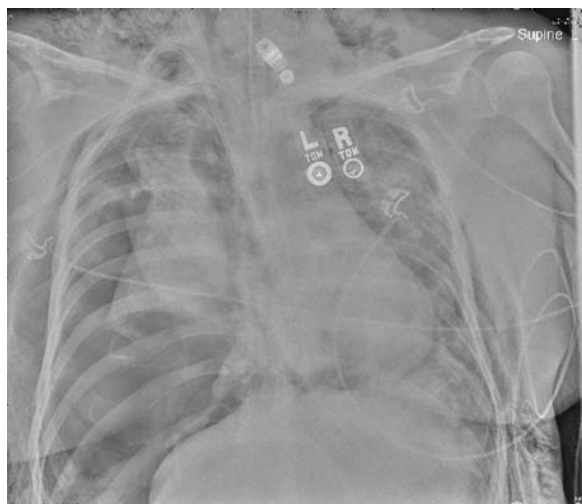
Tension pneumothorax in a patient receiving mechanical ventilation for ARDS. There is a large pneumothorax on the right with associated collapse of the right lung and shift of the heart and mediastinal structures toward the left side of the chest. A smaller left pneumothorax is also present. Although features of chest radiographs, including shift of the mediastinal structures, are strongly suggestive of the diagnosis of tension pneumothorax, the diagnosis is typically made clinically at the bedside before chest radiography is performed.
